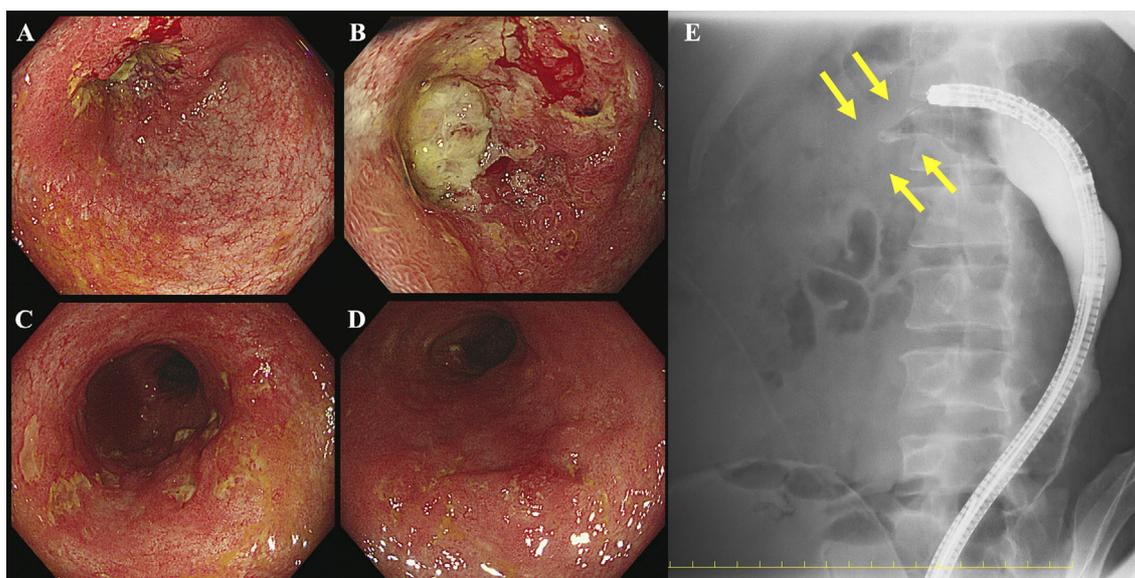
Endoscopic findings and radiographic imaging. An endoscopic examination revealed a large neoplasm with a deep ulcer and mild inflammation in the transverse colon (A, B), moderate to severe inflammation with active ulceration in the sigmoid colon (C), and an irregular flat elevated lesion with moderate active inflammation in the rectum (D). A radiographic imaging demonstrating complete stenosis of the transverse colon (E, yellow arrows).
